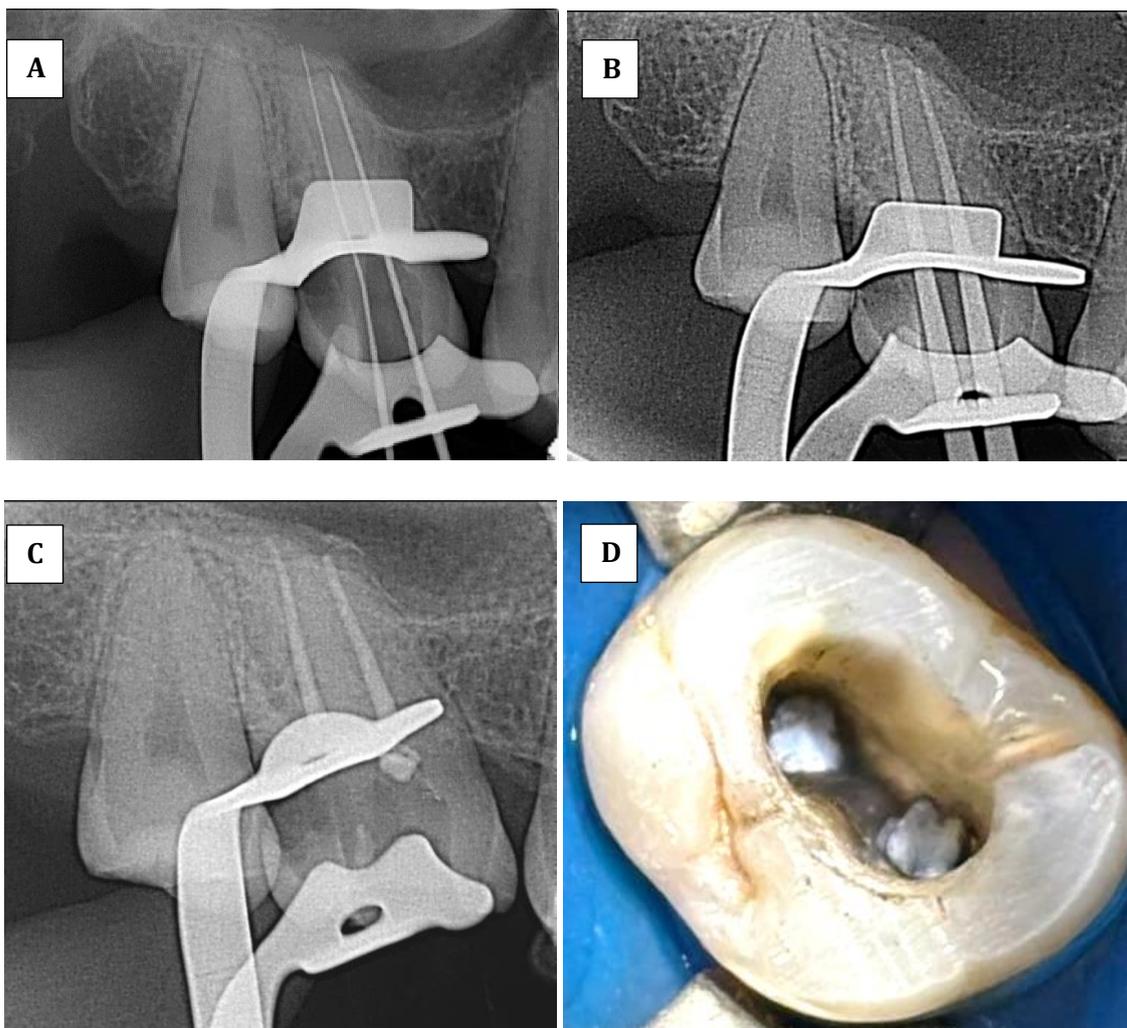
A: Periapical radiograph (PA) image of working length determination, B: PA of master cone verification, C: PA of 3 complete obturation, D: Clinical image of orifices after obturation.
